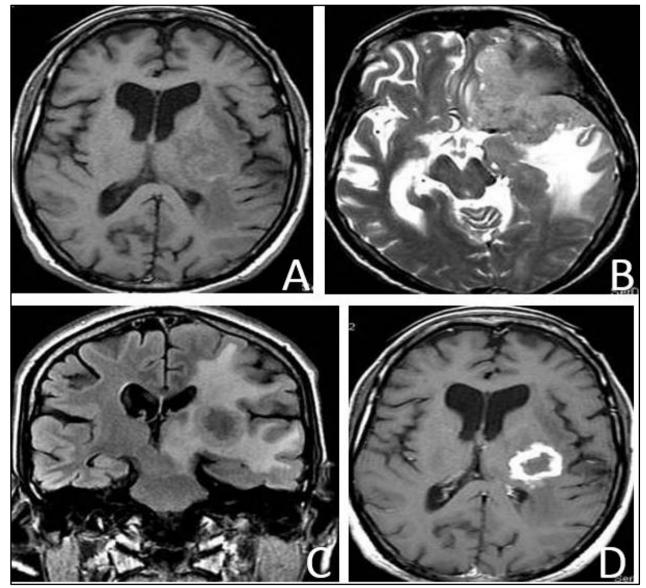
Axial T1 WI (A), Axial T2 WI (B), Coronal FLAIR Image (C) and Axial Contrast Enhanced T1 WI (D) Image showing Irregularly Enhancing Ring Lesion in Left Basal Ganglia and Thalamocapsular Region suggest Tuberculoma
